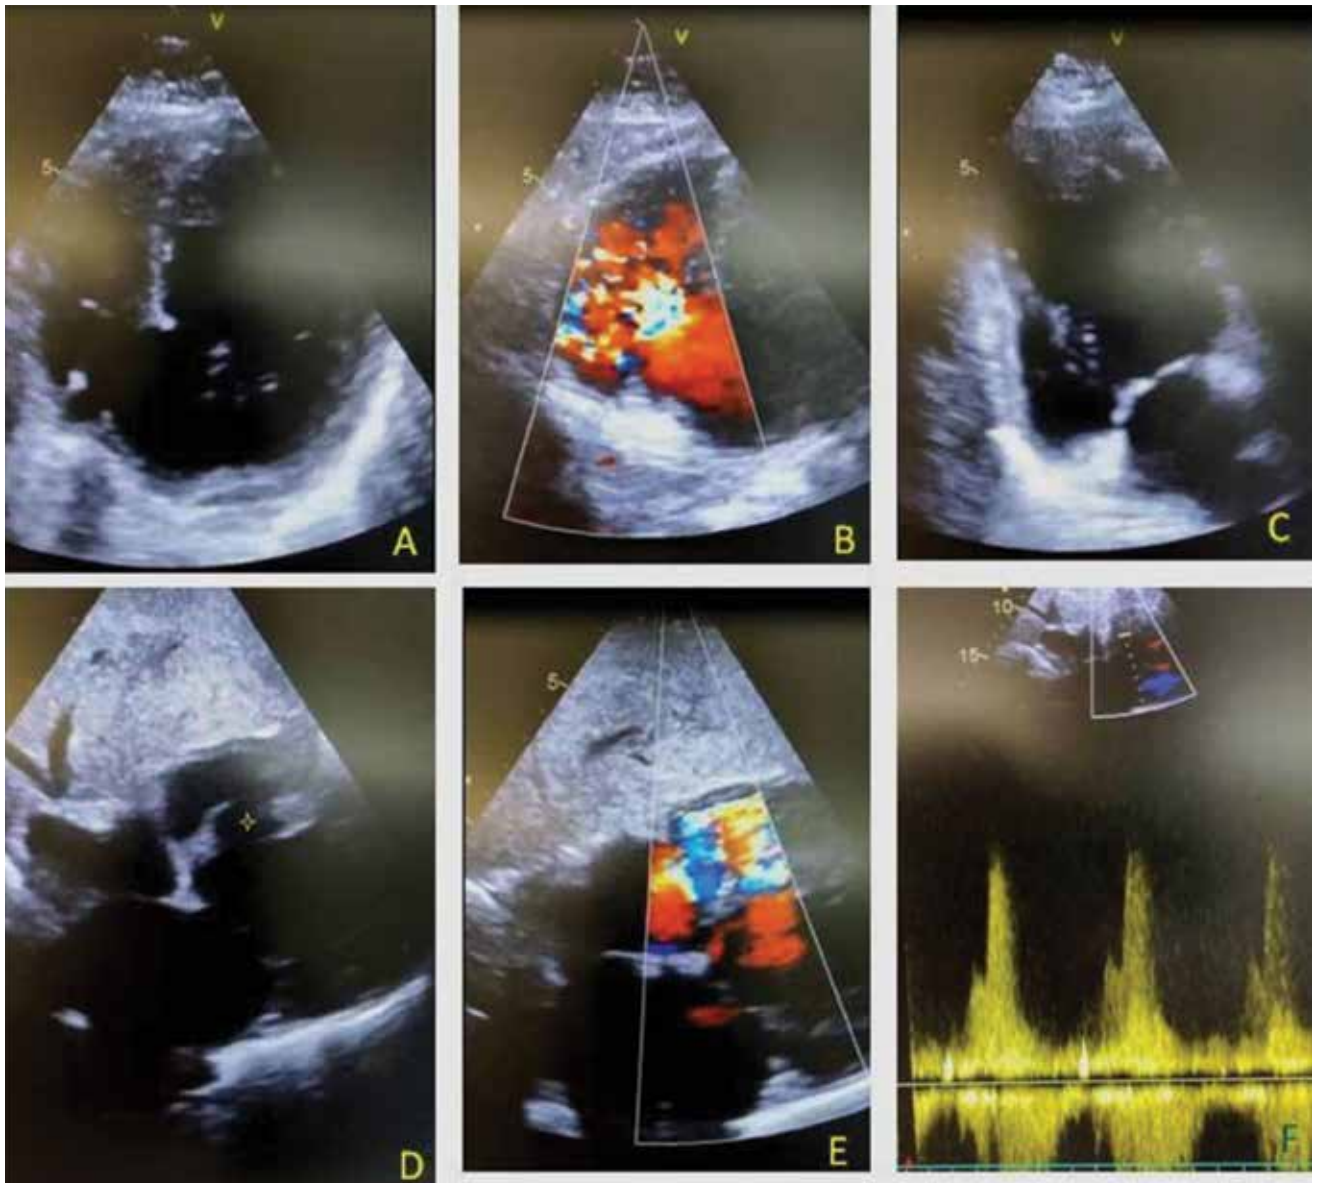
A) Atypical parasternal projection showing large defect of basal inferoseptum. B) Massive turbulent left to right shunt. C) Remodeled left ventricle with inferior wall akinesia (A2C projection). D) Subcostal view of septal defect and corresponding shunt (E). F) CW Doppler of high velocity systolic flow through the defect.
